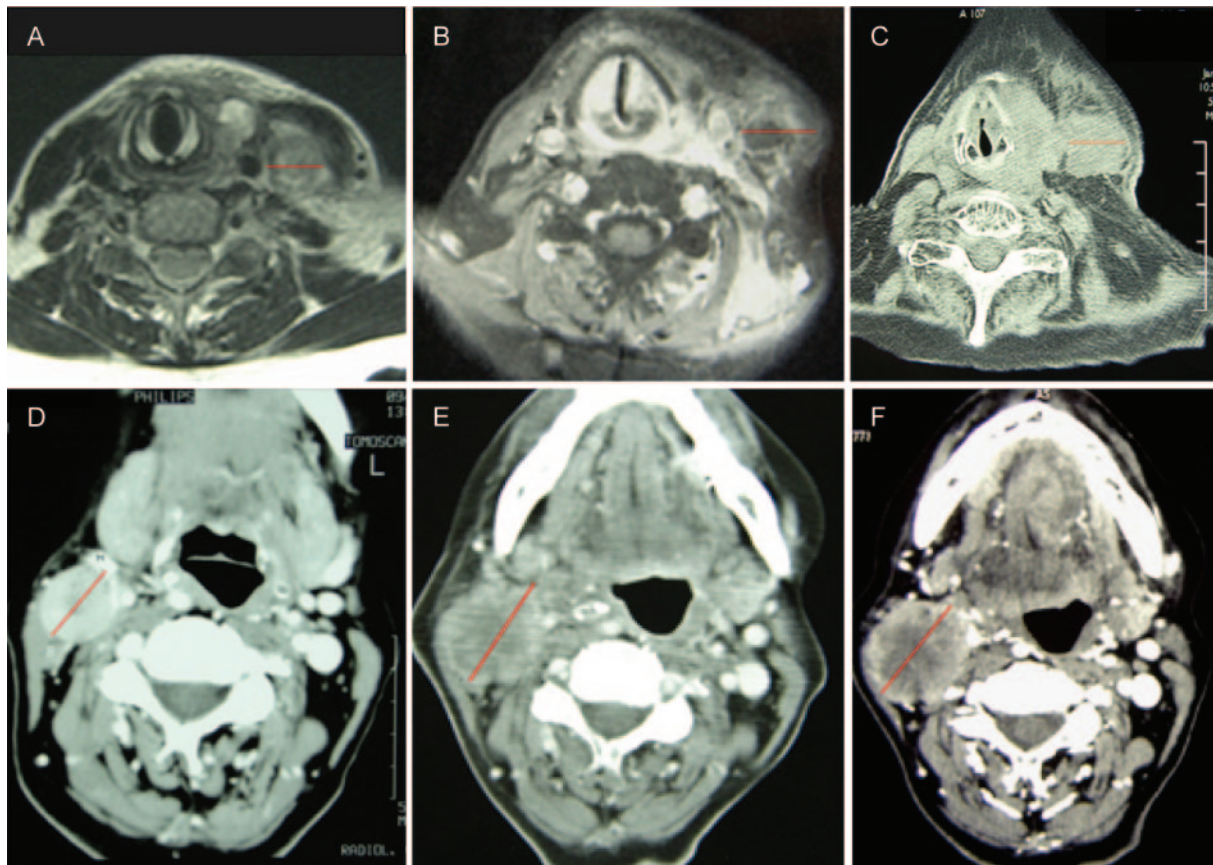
Radiological evaluation of patients undergoing gene therapy. Patient 1 (A–C): In a neck MRI performed before gene therapy, the tumor appeared as a solid mass, which extended mainly in the left posterior cervical region, displaced the larynx and the trachea, and infiltrated C2–C4 cervical vertebrae. A nodule 2 cm in diameter, which was chosen for RVPC injection, is indicated (A). After the first cycle of gene therapy, an MRI scan demonstrated unchanged size, but more inhomogeneous intensity, of the tumor mass injected with RVPCs than in the previous MRI scan (B). A neck CT performed after the second cycle of gene therapy showed a slight reduction of the tumor mass to 1.5 cm in diameter (C). All images represent C6 cervical vertebrae level. Patient 2 (D and E): A neck CT scan performed before gene therapy showed the presence of 4.5-cm tumor mass surrounding and infiltrating the right carotid artery and cervical lymph node metastases of 1.5 and 2.5 in diameter, the largest of which had a marked contrast enhancement. The first cycle of gene therapy consisted of injection of RVPCs into the right cervical mass, 2.5 cm in diameter (D). A neck CT performed after the first cycle of gene therapy showed an increase in tumor mass to 4 cm (E). After the second cycle of gene therapy, a neck CT scan showed a tumor mass of 3.5 cm in diameter with signs of necrosis (F). However, the size and number of lung metastases increased.
